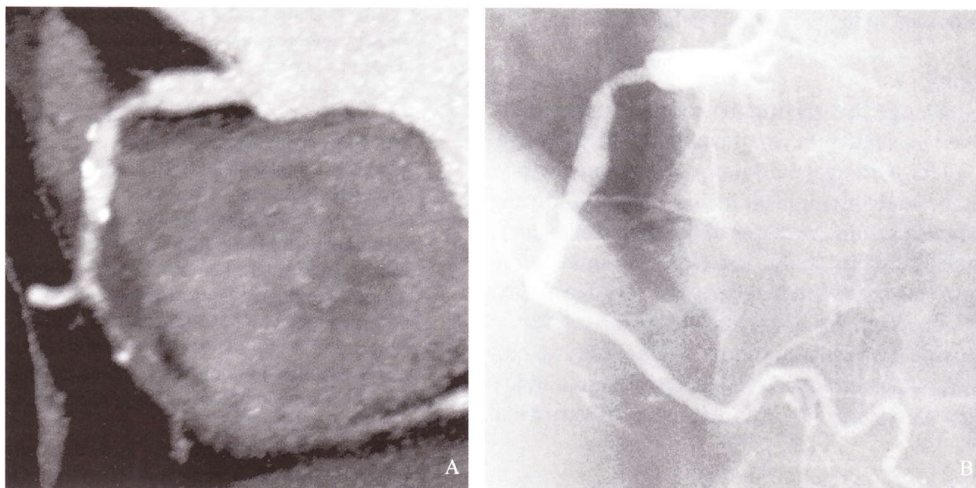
CTA of right coronary artery (A) with poor image quality and corresponding CCA of right coronary artery (B).
